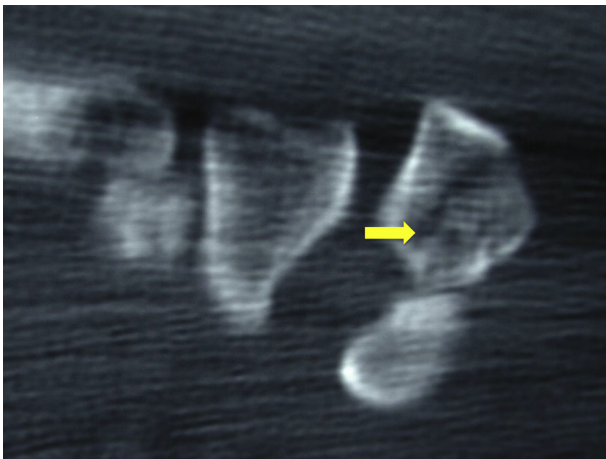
Corresponding CT image showing a fracture of the triquetrum (arrow).
